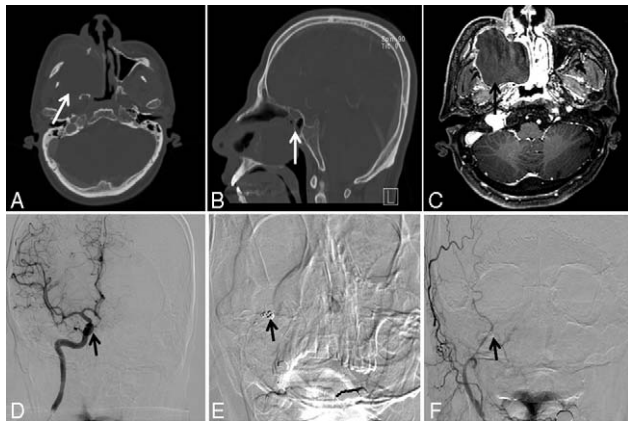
(A) Axial and (B) coronal images of paranasal sinus computed tomography. The bulging mass shows a homogenous density occupying right maxillary sinus with erosion of the posterior wall of maxillary sinus and sphenoid sinusitis (arrow). (C) Axial image of paranasal sinus T1-gadolinium enhanced magnetic resonance imaging. A 6 × 5-cm-sized, gadolinium-enhanced mass with internal cystic change (arrow) can be seen and the lesion is well demarcated with smooth margins. (D) Preembolization angiography. Blood circulation of right internal carotid artery and external carotid artery was checked before embolization. Large pseudoaneurysm (arrow) is noted with feeder of right IMA. (E) Postembolization angiography. Embolization of right IMA (arrow) was done using n-butylcyanoacrylate and platinum coils. (F) Postembolization angiography. After embolization, no bleeding is noted from right IMA (arrow). IMA, internal maxillary artery.
